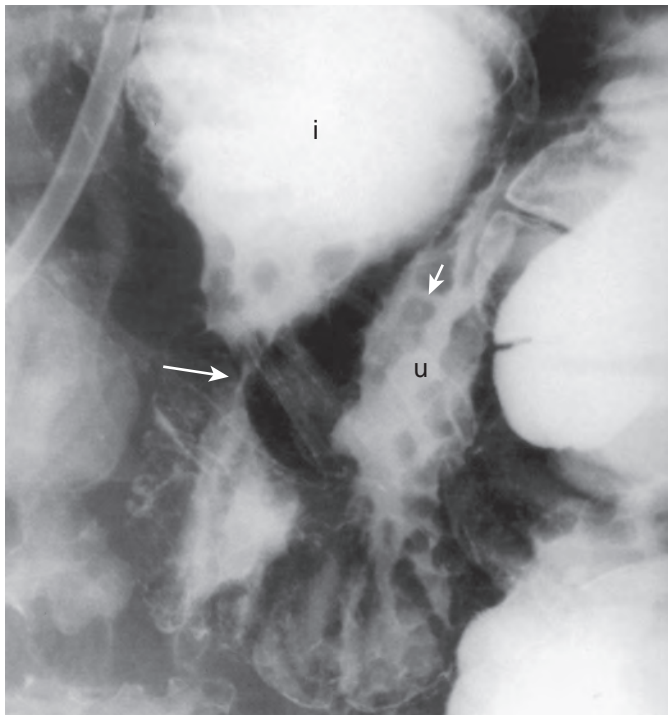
Crohn's disease causing partial small bowel obstruction. Spot radiograph from enteroclysis demonstrates a dilated ileum (i) proximal to a 1 cm in length by 1 mm in luminal diameter stricture (long arrow). An ulceronodular pattern (cobblestoning; u) is seen in the ileum distal to the stricture, manifested as transverse and longitudinal barium-filled, knifelike clefts or ulcers (short arrow) separating polygonal islands of relatively spared mucosa. (Courtesy Hans Herlinger, MD.)
